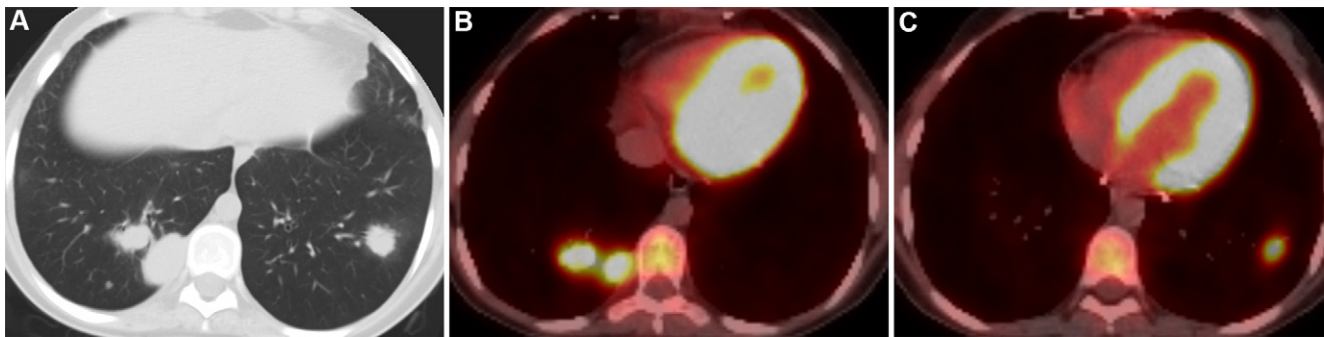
Images in a 24-year-old man with posttransplant lymphoproliferative disease identified 18 months after bilateral lung transplantation for cystic fibrosis. (A) Axial chest CT and (B, C) axial fluorodeoxyglucose PET/CT images show spiculated bilateral pulmonary nodules with intense fluorodeoxyglucose avidity.
